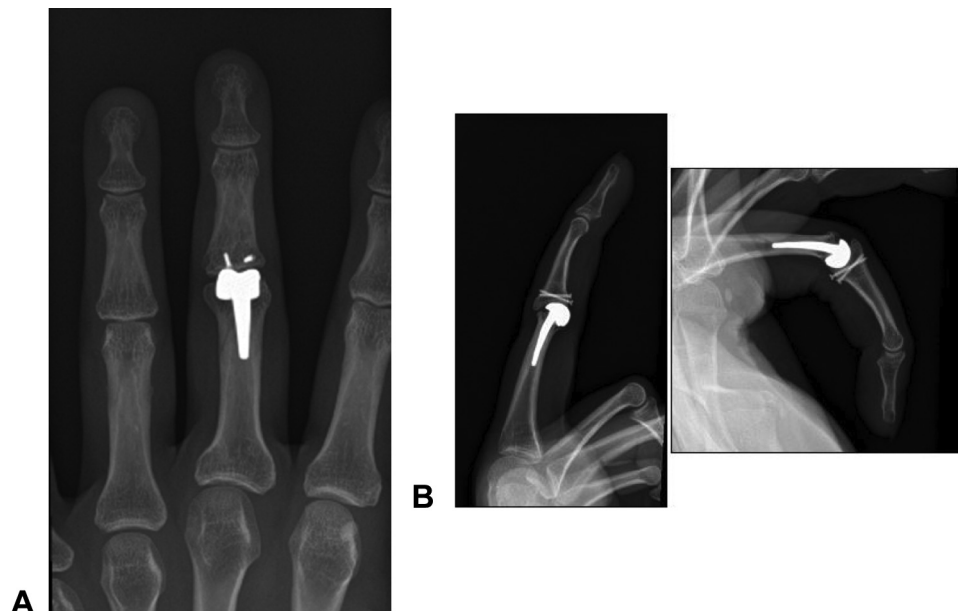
A Posteroanterior and B lateral radiographs 12 years after middle finger hemi-hemi PIP joint reconstruction.
